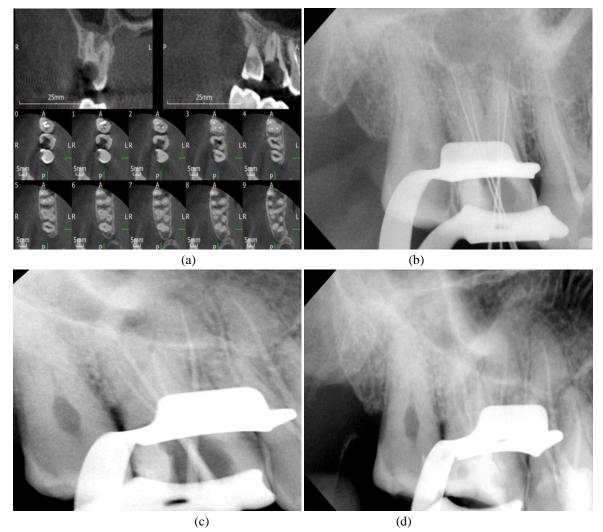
a) CBCT showing axial section of tooth presenting 4 roots 4 canals (17). b) radiograph showing working length determination c) radiograph showing master apical file. d) radiograph showing obturation
